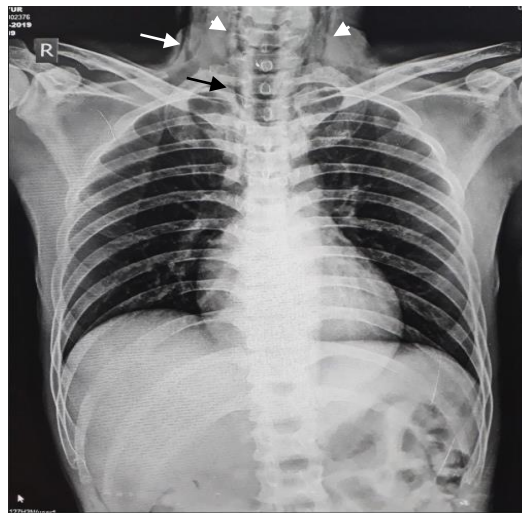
AP position chest radiograph showing linear lucency along the bilateral paratracheal planes (arrowheads). A lucent shadow surrounds the bilateral brachiocephalic trunk with a tubular artery sign (black arrow). And also found a lucent shadow in the Colli region impression on soft tissue (white arrow)
